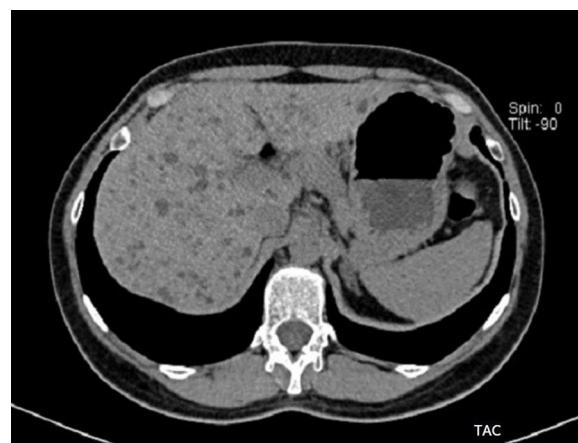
Computed tomography: Axial view of the upper abdomen showing multiple small, low-attenuation liver lesions.
